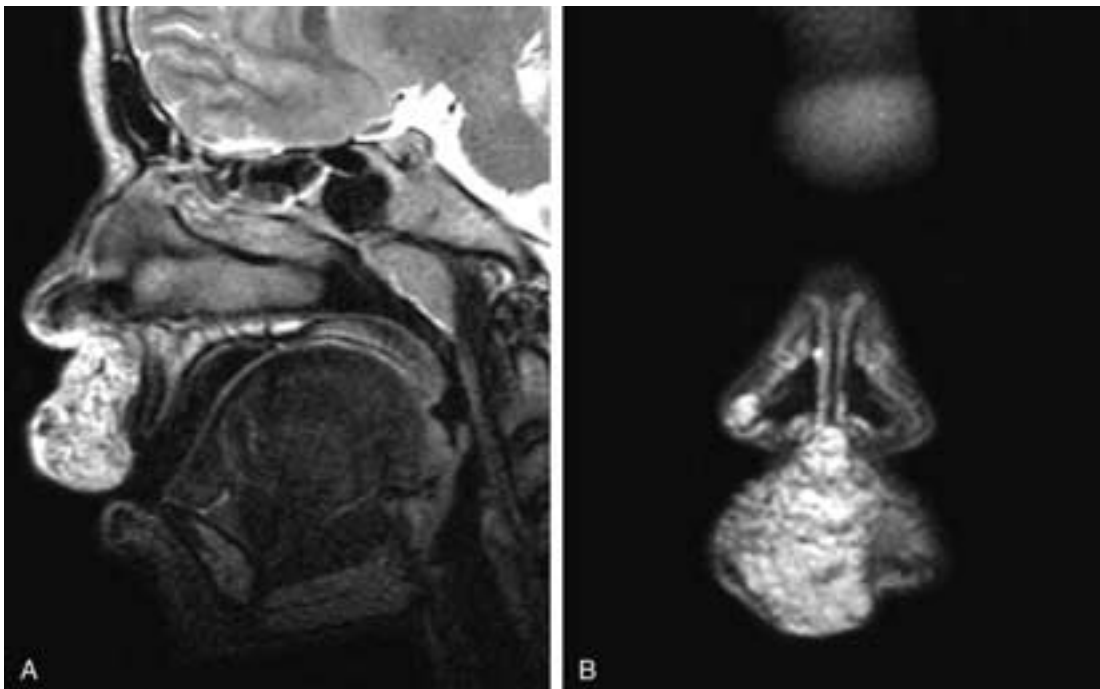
Sagittal (A) and coronal (B) T2-weighted MR images shows a mass with vascular flow voids within the columella and upper lip. The lesion also extended back into the right cheek. This was a vascular malformation in a 12-year-old girl.
